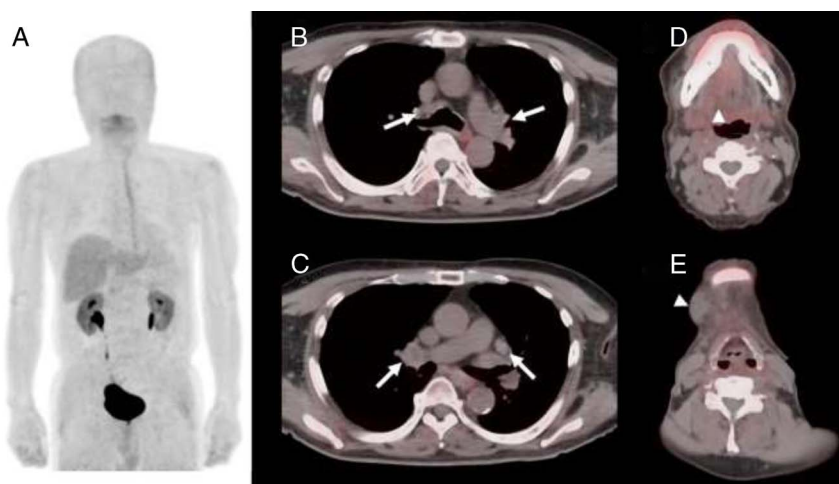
The following day after ^{18}F -FDG PET, ^{18}F -fluoro-boronophenylalanine (FBPA) PET was performed. No significant FBPA uptake was observed in the mediastinal and hilar lymph nodes (A–C, arrows), or in the inflammatory lesion from the right side of the tongue to the right submandibular region (D and E, arrowheads), suggesting its specificity as an L-type amino acid transporter 1 (LAT1).^{1–4} LAT1 is a cancer-type amino acid transporter that shows minimal expression in inflammatory lesions.^{1,5} ^{18}F - α -methyl tyrosine, another LAT1-specific PET probe, was also reported to show no significant uptake in sarcoidosis lesions.^{6–8} ^{18}F -FBPA PET can be used for precise evaluation of oncology patients in which the differentiation between reactive uptake and metastatic uptake is inconclusive on ^{18}F -FDG PET.
